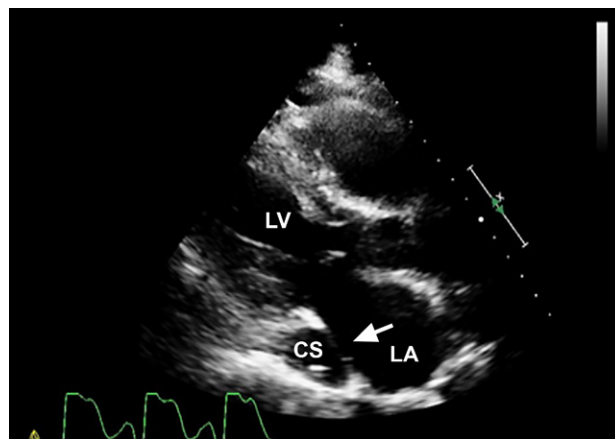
Transthoracic echocardiogram shows a dilated coronary sinus (CS) and the pacemaker leads (arrow).
